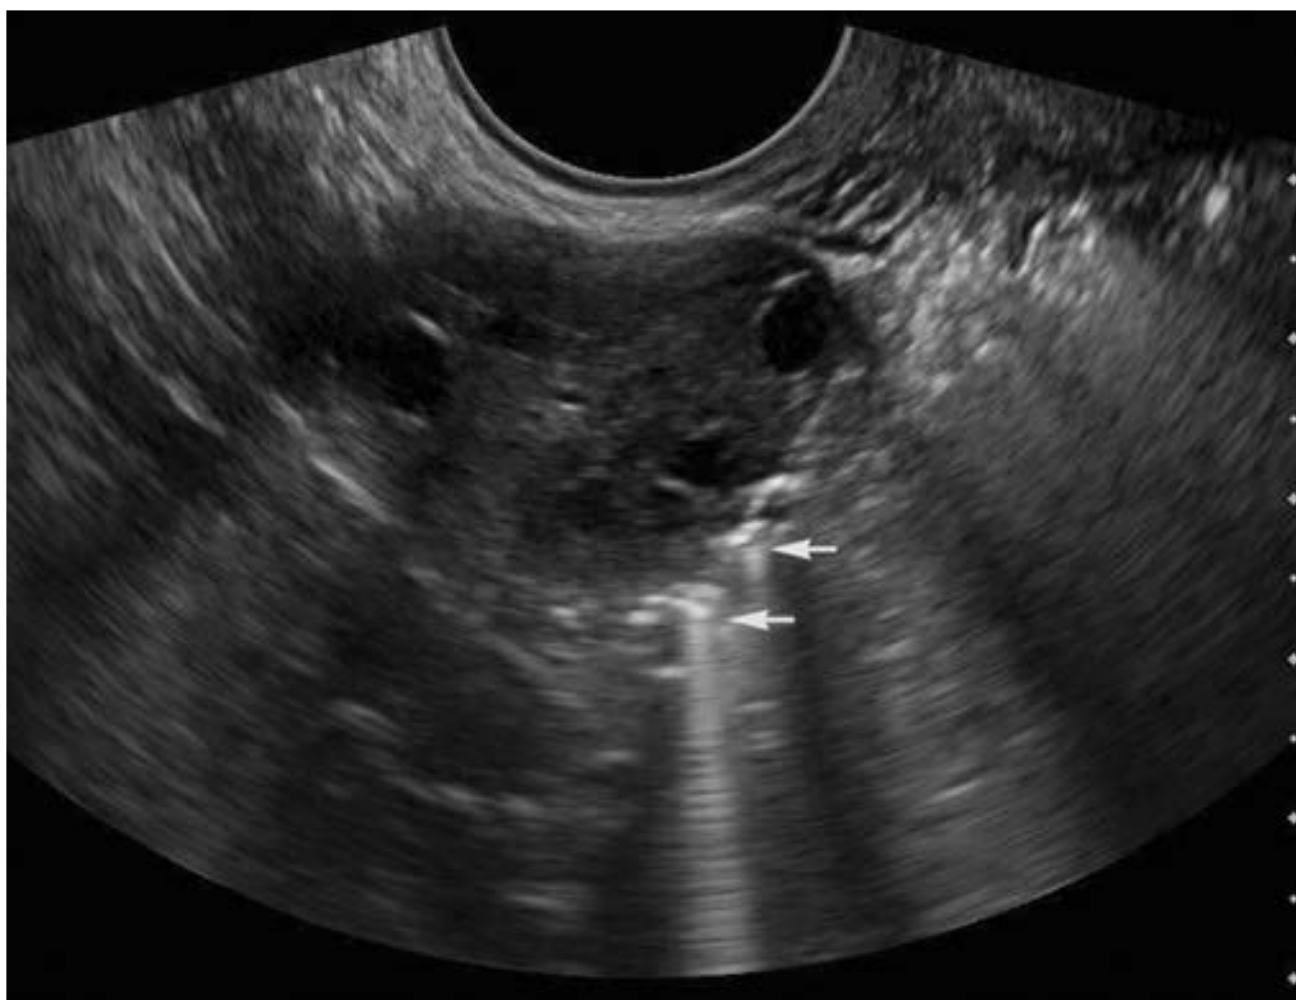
Transvaginal image of an ovary with echogenic bubbles adjacent to it (arrows) as seen during hysterosalpingo-contrast sonography (HyCoSy). The air in the saline contrast produces the bright echoes and ring-down artifacts. Visualization of these echoes adjacent to the ovary represents contrast exiting the tube, consistent with tubal patency.
